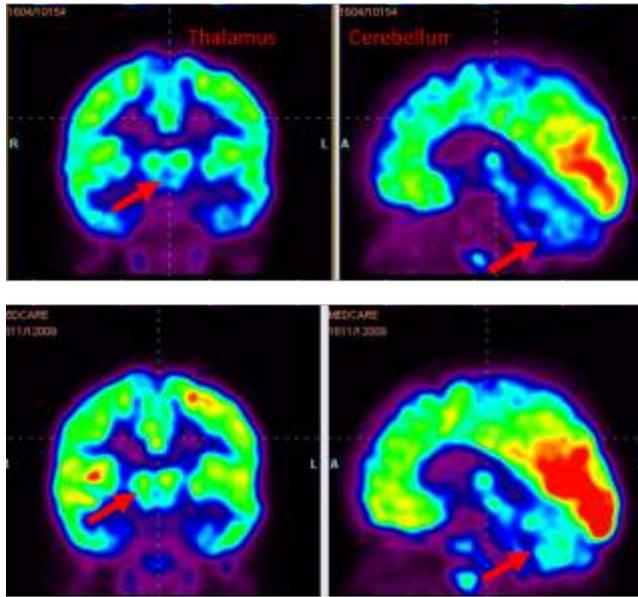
Comparative PET CT scan showing improved metabolism in CP. Before stem cell therapy PET CT showed reduced metabolism in left motor cortex, bilateral medial temporal cortex, bilateral Basal ganglia, Bilateral cerebellum. After stem cell therapy, improvement was seen in left motor cortex, significant improvement in bilateral basal ganglia, Thalamus and bilateral cerebellum
